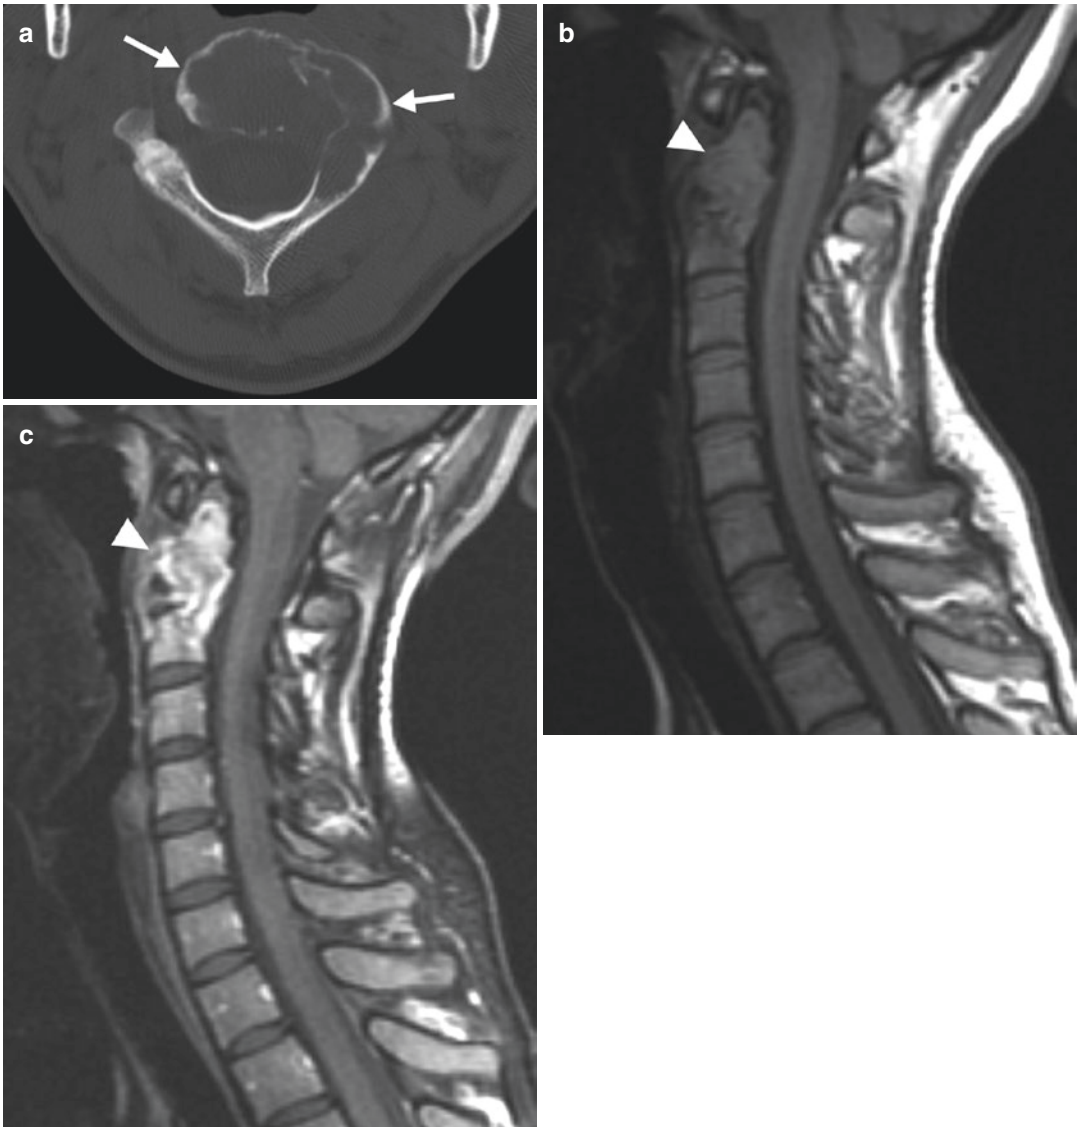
A 31-year-old woman with an osteoblastoma of the C2 vertebral body, left pedicle, and lamina. (a) Axial CT demonstrates a lucent, non-mineralized lesion (*arrows*) with expansile remodeling and focal effacement
